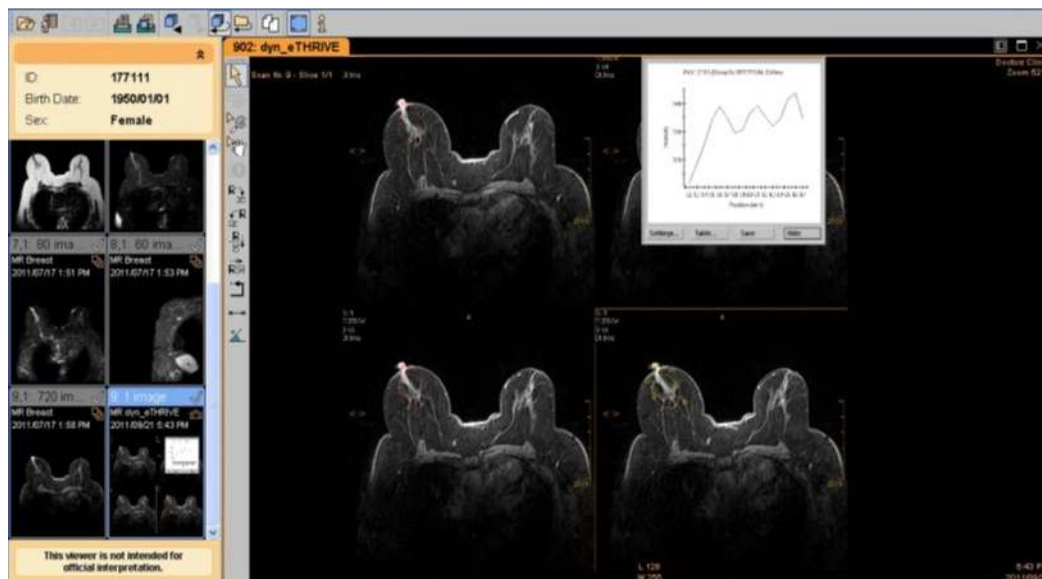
DCE-MRI of the right breast in a 40 year old female, which shows an intraductal papilloma. The time intensity curve was raised in 2 minutes and progress wash out using type 111 curves
